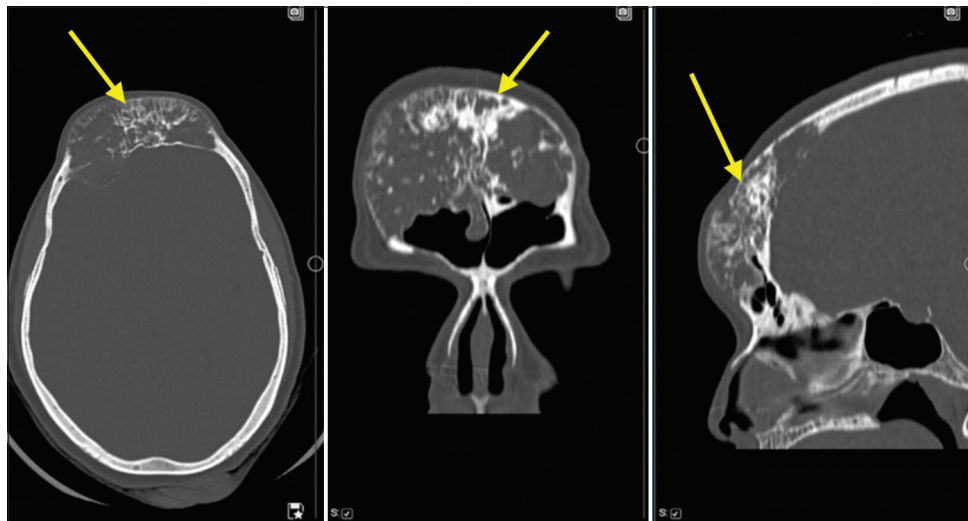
Non-contrast computed tomography (bone-window) images showing a well-circumscribed expansile lytic lesion in the right frontal bone diploic space with coarse trabeculae radiating from a central focus, creating a “sunburst” pattern
